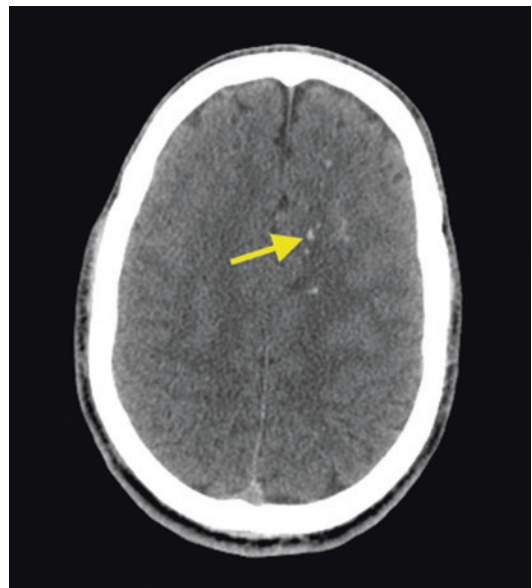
Unenhanced CT of the head after motorcycle accident highlights the presence of subarachnoid hemorrhage and microhemorrhages in the corona radiata
